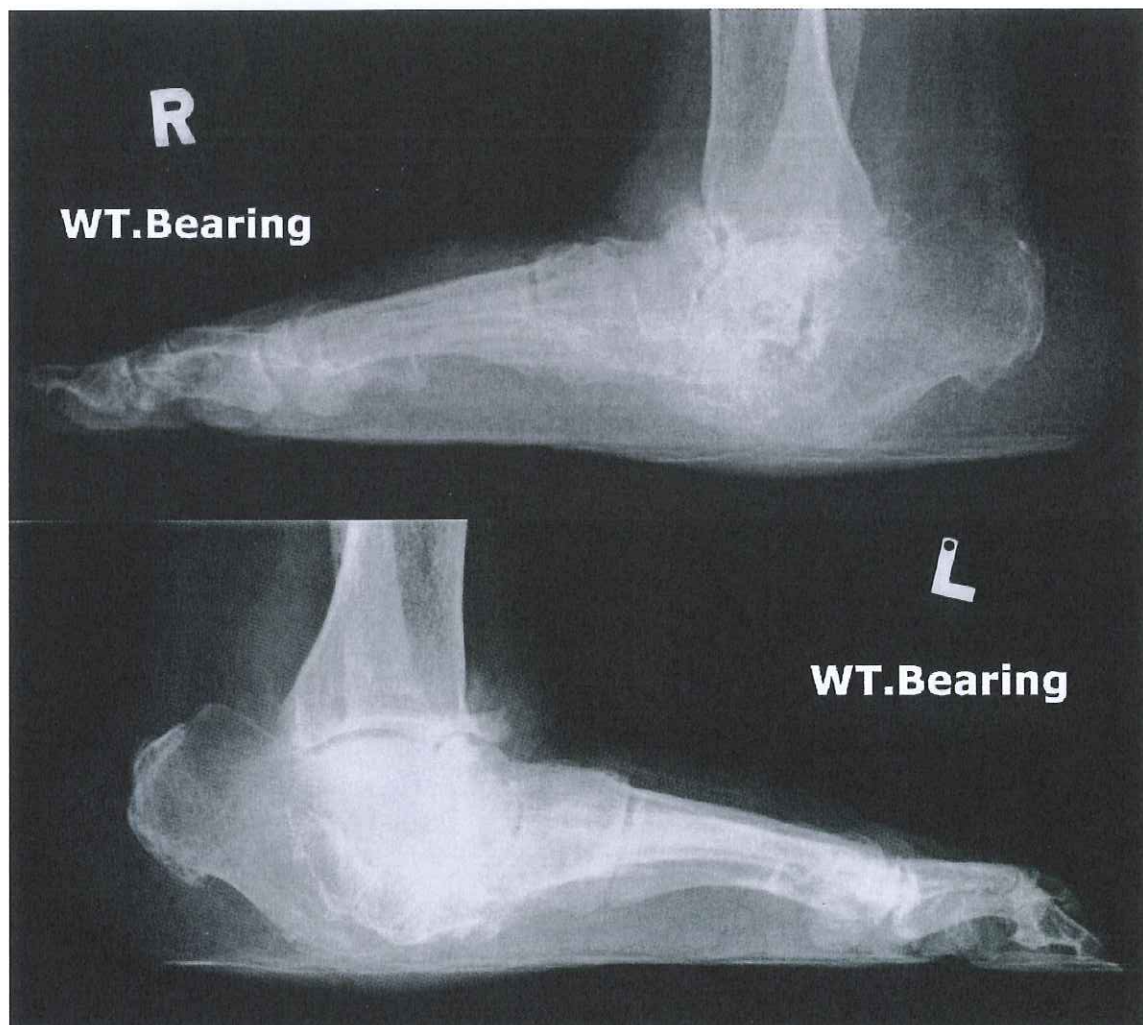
Radiographs of the lateral view of the feet of the 70-year-old lady with diabetes mellitus.
